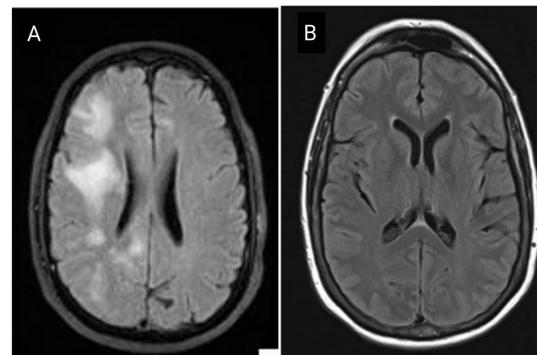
MRI of a classic PML patient⁴ (A) and our case study (B). Multiple lesions with demyelination are seen in the classic PML patient, while the case study patient has no apparent lesions.
